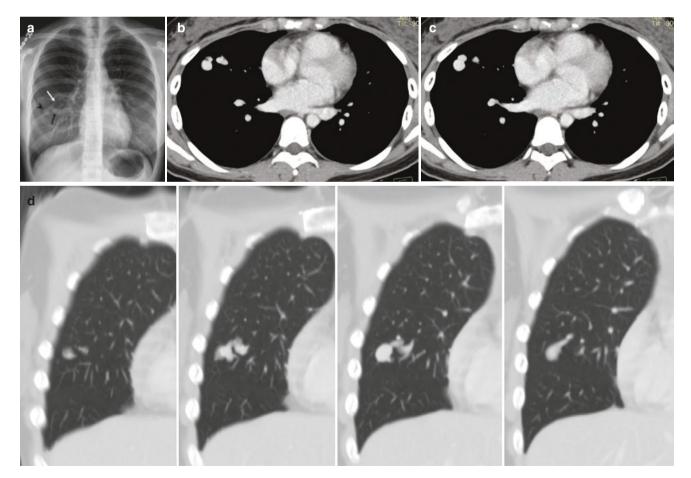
A 23-year-old woman with right lung arteriovenous malformation (AVM). (a) Frontal chest radiograph shows a nodular opacity in the right mid-lower zone (arrowhead) with tubular vessels coursing toward it from the hilum (arrows). (b, c) Axial contrast-enhanced CT
